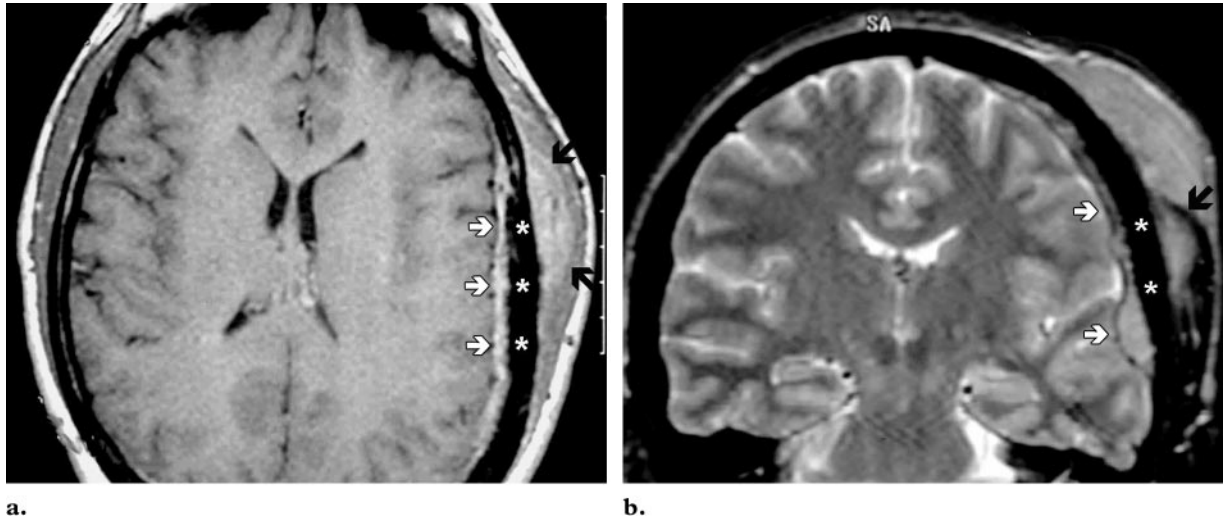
Non-Hodgkin lymphoma with transcalvarial infiltration in an 18-year-old man with a left-sided calvarial mass and no other symptoms. Axial contrast-enhanced T1-weighted (a) and coronal T2-weighted (b) MR images show abnormal signal intensity of bone marrow (*) with an extraosseous subperiosteal (black arrows) and epidural (white arrows) enhancing soft-tissue mass. Surgical biopsy demonstrated a non-Hodgkin lymphoma.
